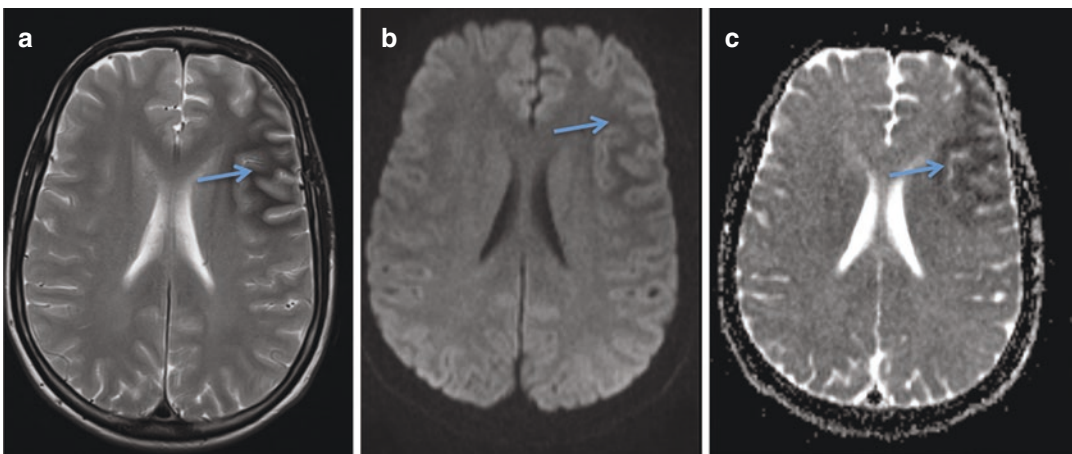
A 18-year-old man presented with somnolence and dysphasia. Blood sugar was 600 mg/dl. MRI showed signal changes in the left lateral frontal lobe: The cortical
